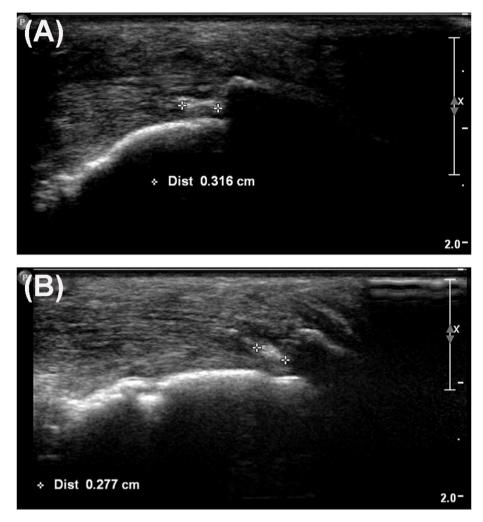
Ultrasonography images revealed the calcification in the Achilles tendon before treatment (A) and after treatment (B). No obvious change of calcification was noted after treatment.
